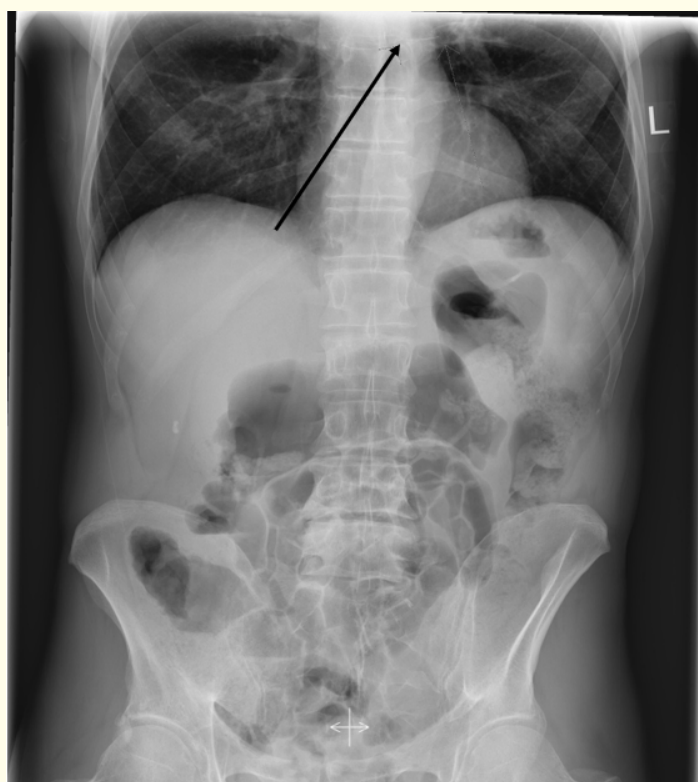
Posterior-anterior abdomen X-ray.
